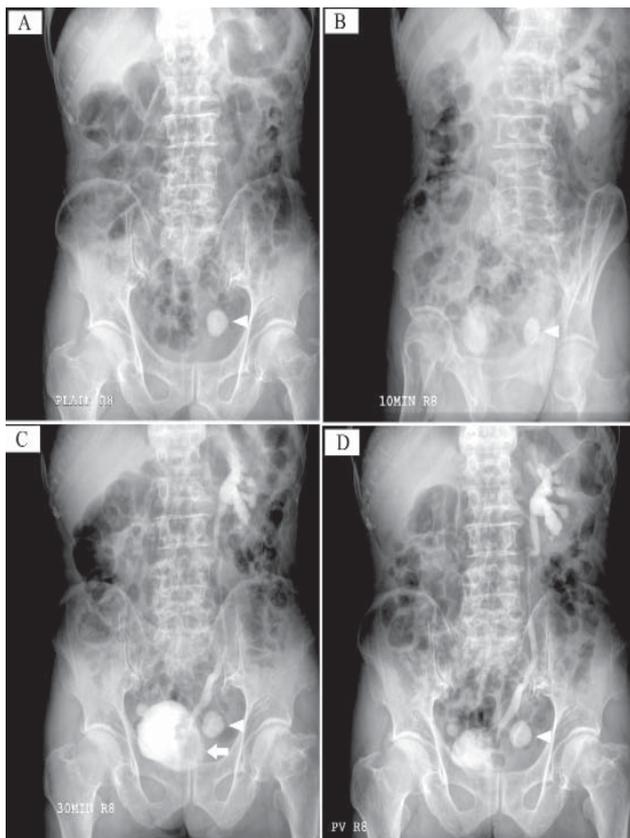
Intravenous pyelography demonstrating radiolucent filling defects projecting into the bladder (arrow) and an extra-vesical calcification (arrowhead). A: Plain film of the abdomen. B: Ten minutes after administration of intravenous contrast medium, oblique view. C: Film of 30 minutes. D: Postvoiding film.
